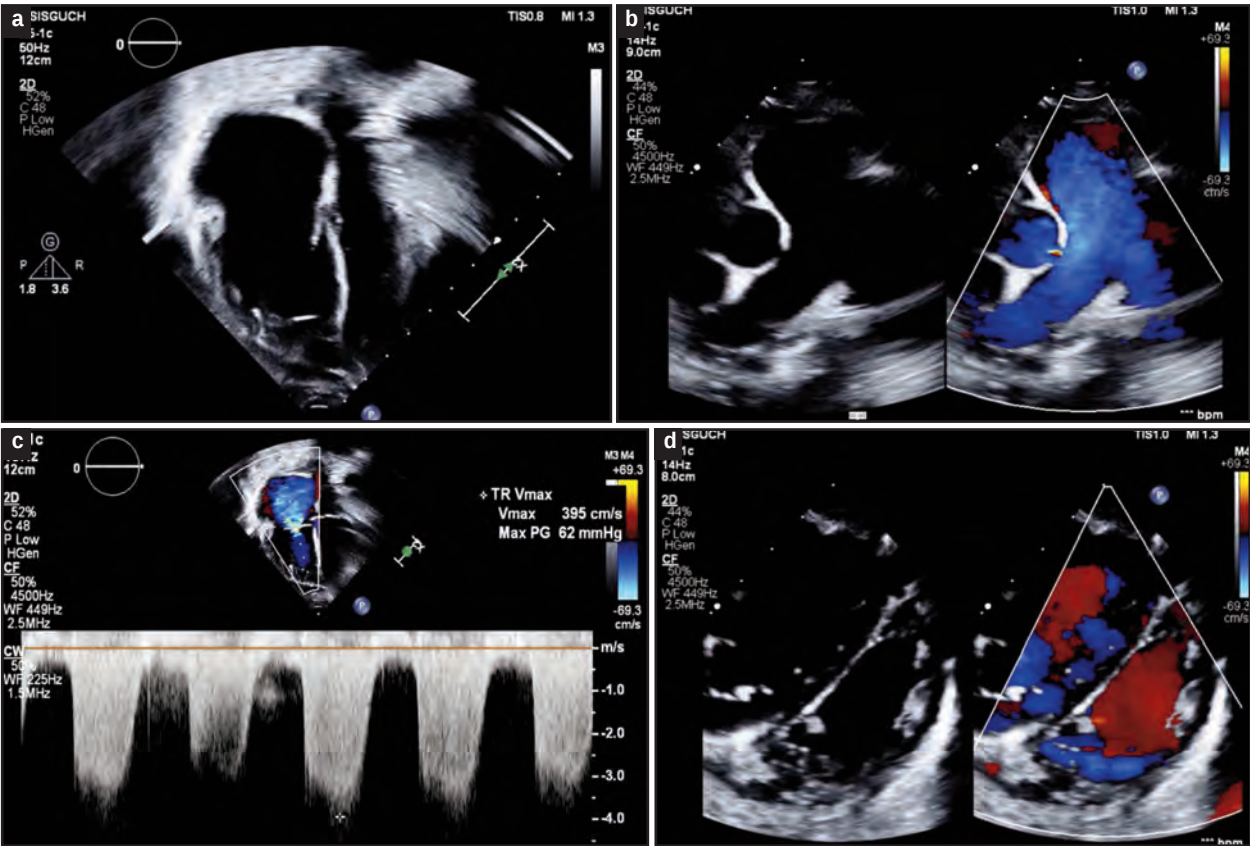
Pre-treatment Echocardiogram; (a) Dilated right-sided chambers (b) Dilated pulmonary arteries (c) Severe tricuspid regurgitation with TR of 62mmHg (d) Interventricular septal flattening
